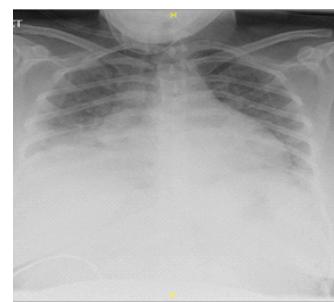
Chest radiograph in keeping with Covid-19 pneumonitis.
